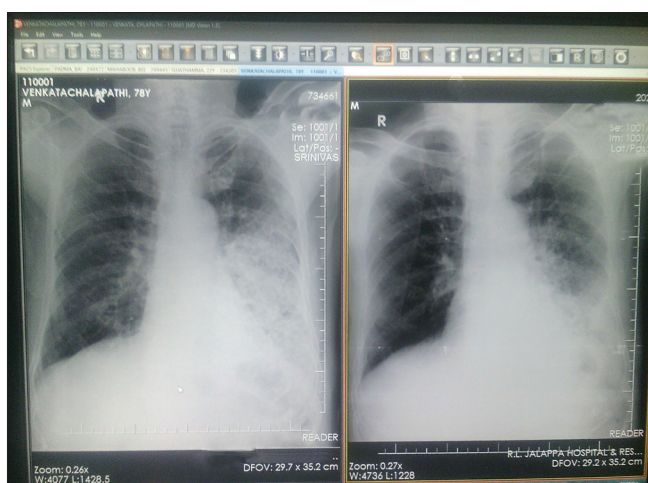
Chest X-ray shows massive consolidation of left lower and middle lobe of the lung and chest X-ray shows resolution of pneumonic patch following treatment with levofloxacin
